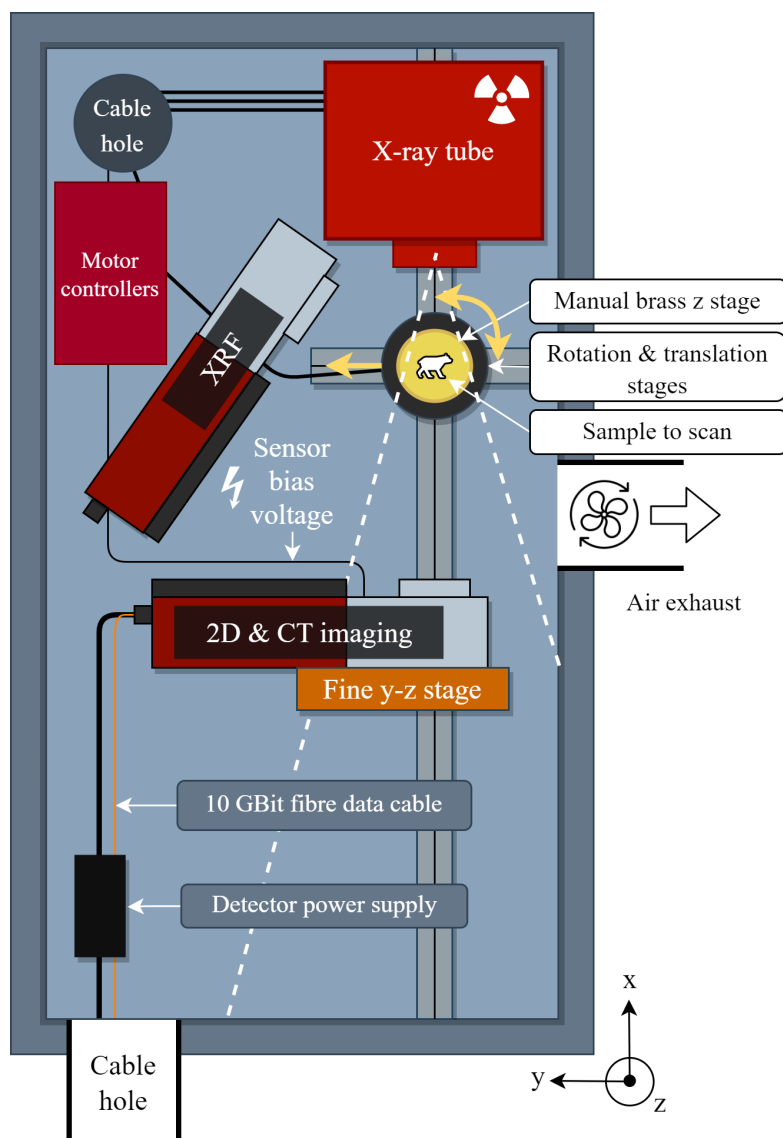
The experimental setup overview with two layouts, one for XRF measurements (outside the main beam) and the other for 2D and CT imaging. The white dashed lines diverging from the x-ray tube represent the approximate shape of the x-ray radiation emission. The manually controlled brass z-stage is on the rotation stage which rotates in the x-y plane. The coordinate system is in the lower right.
